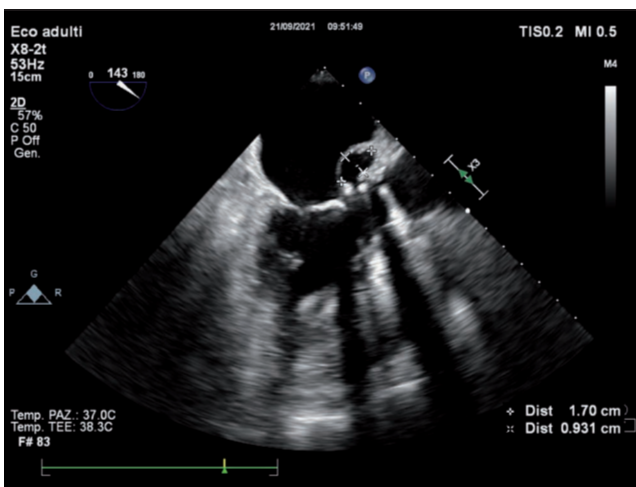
2D transesophageal echocardiography images of an aortic pseudoaneurysm.
